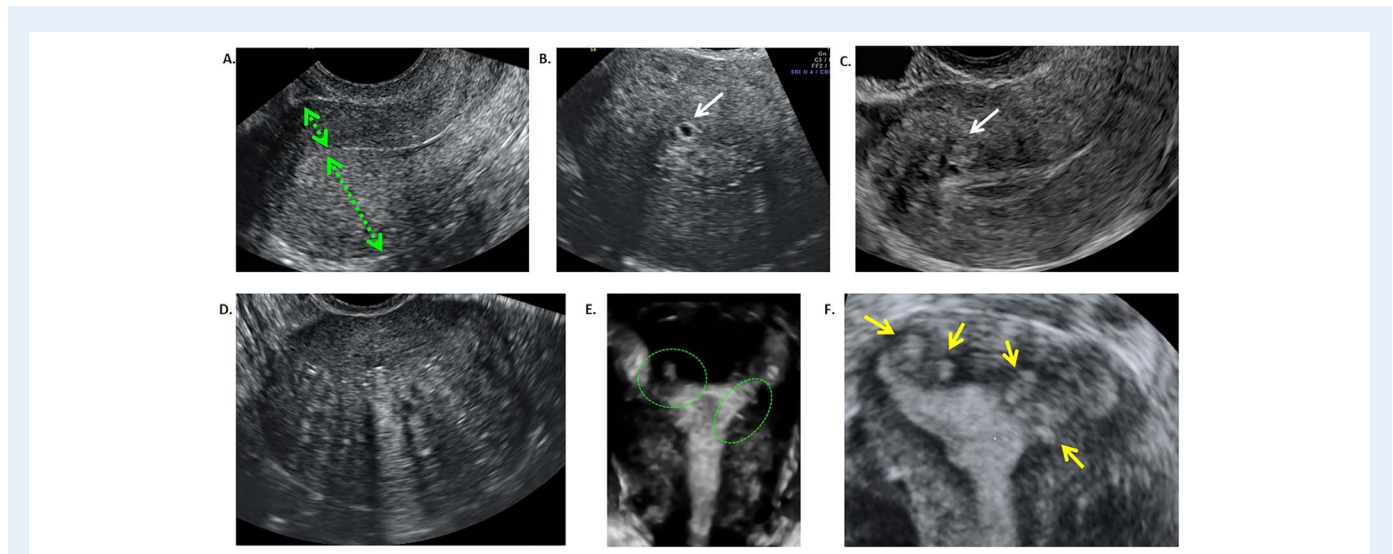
Two-dimensional (2D) and three-dimensional (3D) transvaginal ultrasound sonography (TVUS) signs of adenomyosis. (A) asymmetry of uterine walls thickness; (B) intramyometrial cysts; (C) intramyometrial hyperechoic islands; (D) myometrium with fan-shaped shadowing; (E) hyperechoic sub-endometrial lines of buds in 3D coronal view of the uterus, as signs of junctional zone (JZ) interruption; (F) JZ interruption in multiple sites visible at 3D coronal view.
